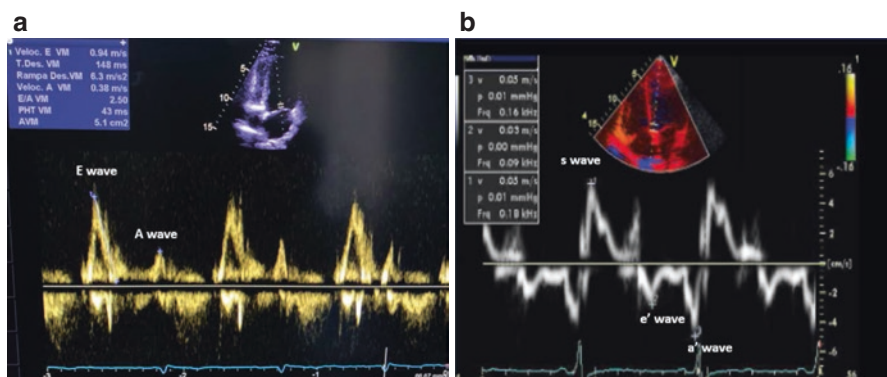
Signs of diastolic dysfunction in a male patient with Anderson–Fabry disease cardiomyopathy. (a) Pulsed Doppler waves of the transmitral flow with $E/A = 2.5$, (b) Tissue Doppler waves of the medial mitral annulus with low-velocity values. $E/e' = 23.5$ (increased left ventricle's filling pressure) in an enlarged left atrium
